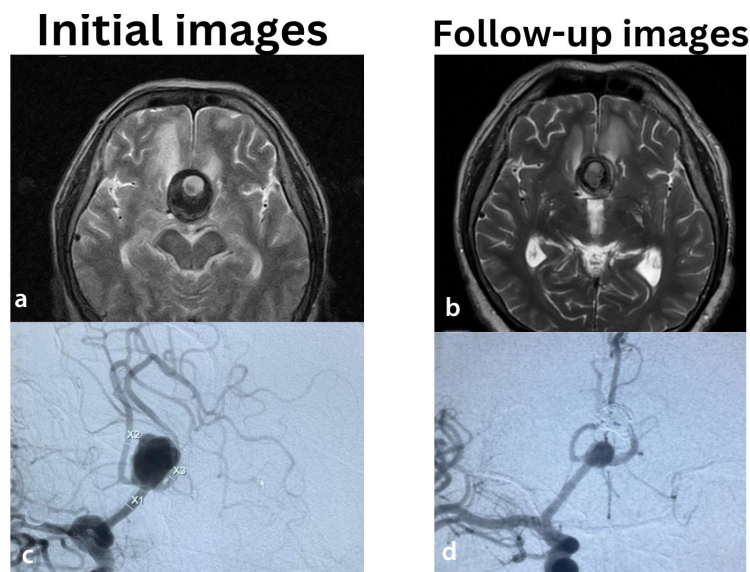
Patient #7. (a) Axial T2 Propeller magnetic resonance imaging showing a large partially thrombosed anterior communicating artery (ACoM) aneurysm measuring $37 \times 33 \times 28$ mm on initial presentation on 09/14/2022, with perianeurysmal edema. (b) Axial T2 image from the control presentation on 04/11/2024, showing signs of aneurysm shrinkage measuring $29 \times 28 \times 26$ mm. (c) Initial angiogram in the working projection demonstrating a large contrast-filled aneurysm measuring $10.7 \times 11.4 \times 15$ mm arising from ACoM. (d) At 3 years of follow-up, O'Kelly–Marotta grade 3B and class 3 according to the modified Cekirge–Saatci classification.
